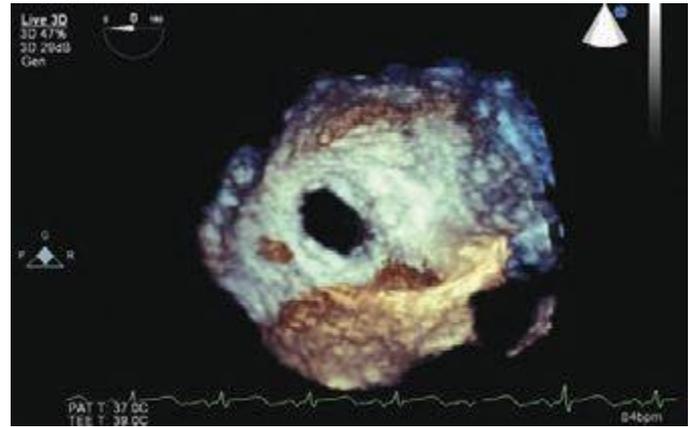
17 Three-dimensional echocardiographic reconstruction of the secundum ASD. The ASD is round and has an acceptable margin of tissue to seat a septal occluder device.
